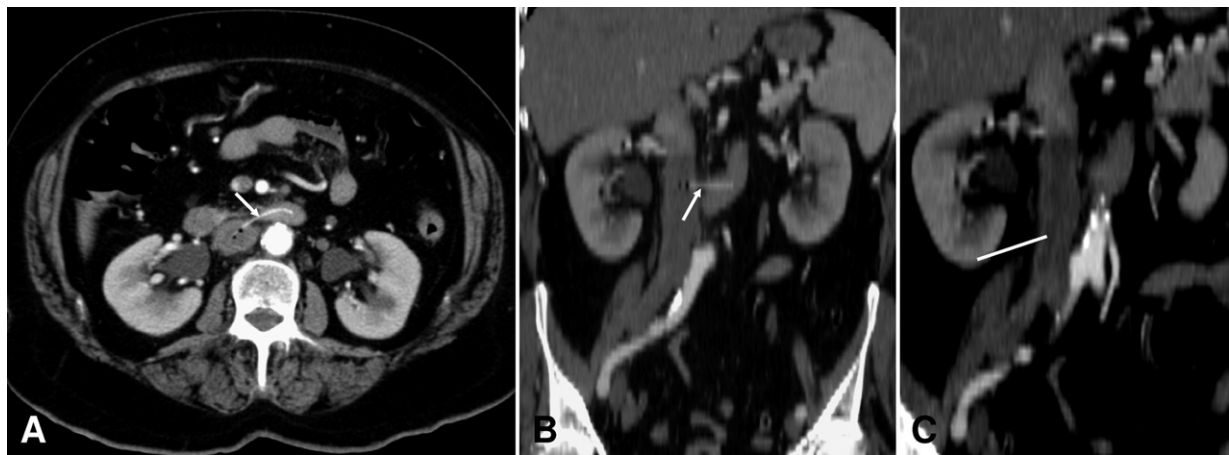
A and B, cross-sectional and coronal reconstruction CT scan demonstrating a duodenocaval fistula resulting from an arciform fish bone perforation (*white and black arrows*); bubbles of gas can be noted inside the inferior vena cava. C, coronal reconstruction CT scan showing partial thrombosis of IVC (*white line*).
